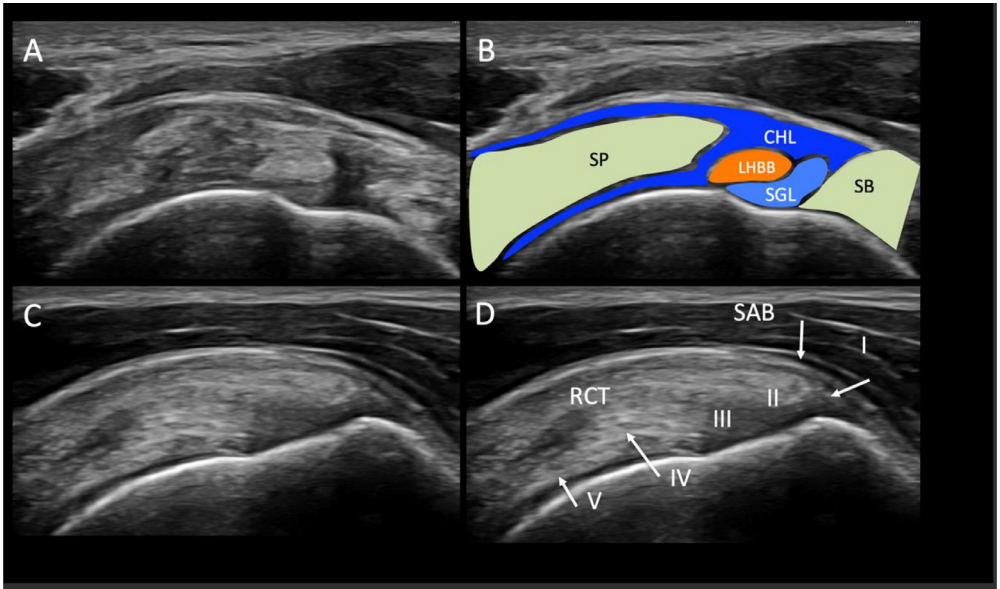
Rotator cuff structures in a longitudinal ultrasound view. CHL, coracohumeral ligament; LHBB, long head of biceps brachialis tendon; SB, subscapularis; SGL, superior glenohumeral ligament; SP, supraspinatus; RCT, rotator cuff tendon.
